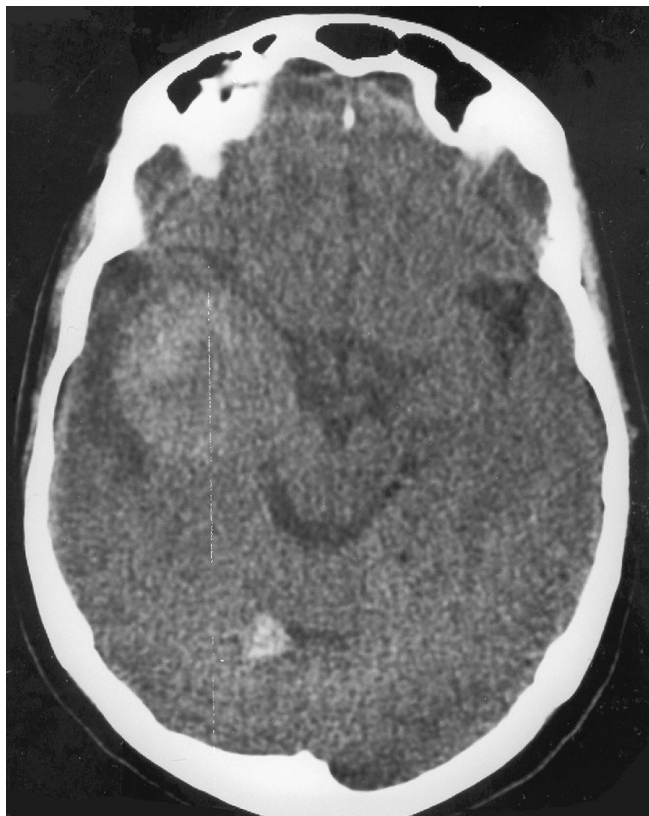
Diagnostic images of patient. Cranial CT show hyperdense lesions in the right temporal, right parietal, and left frontal lobar areas.
